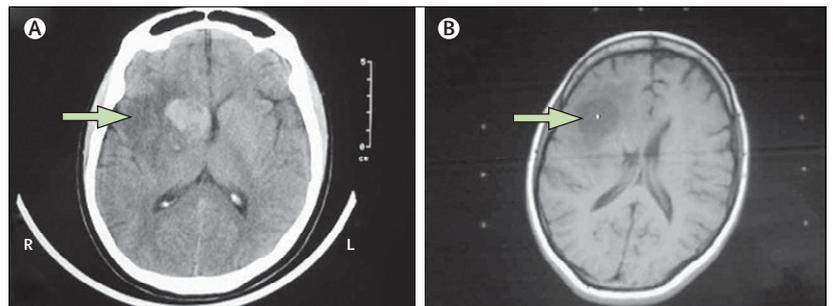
CT scans of the patient's head
